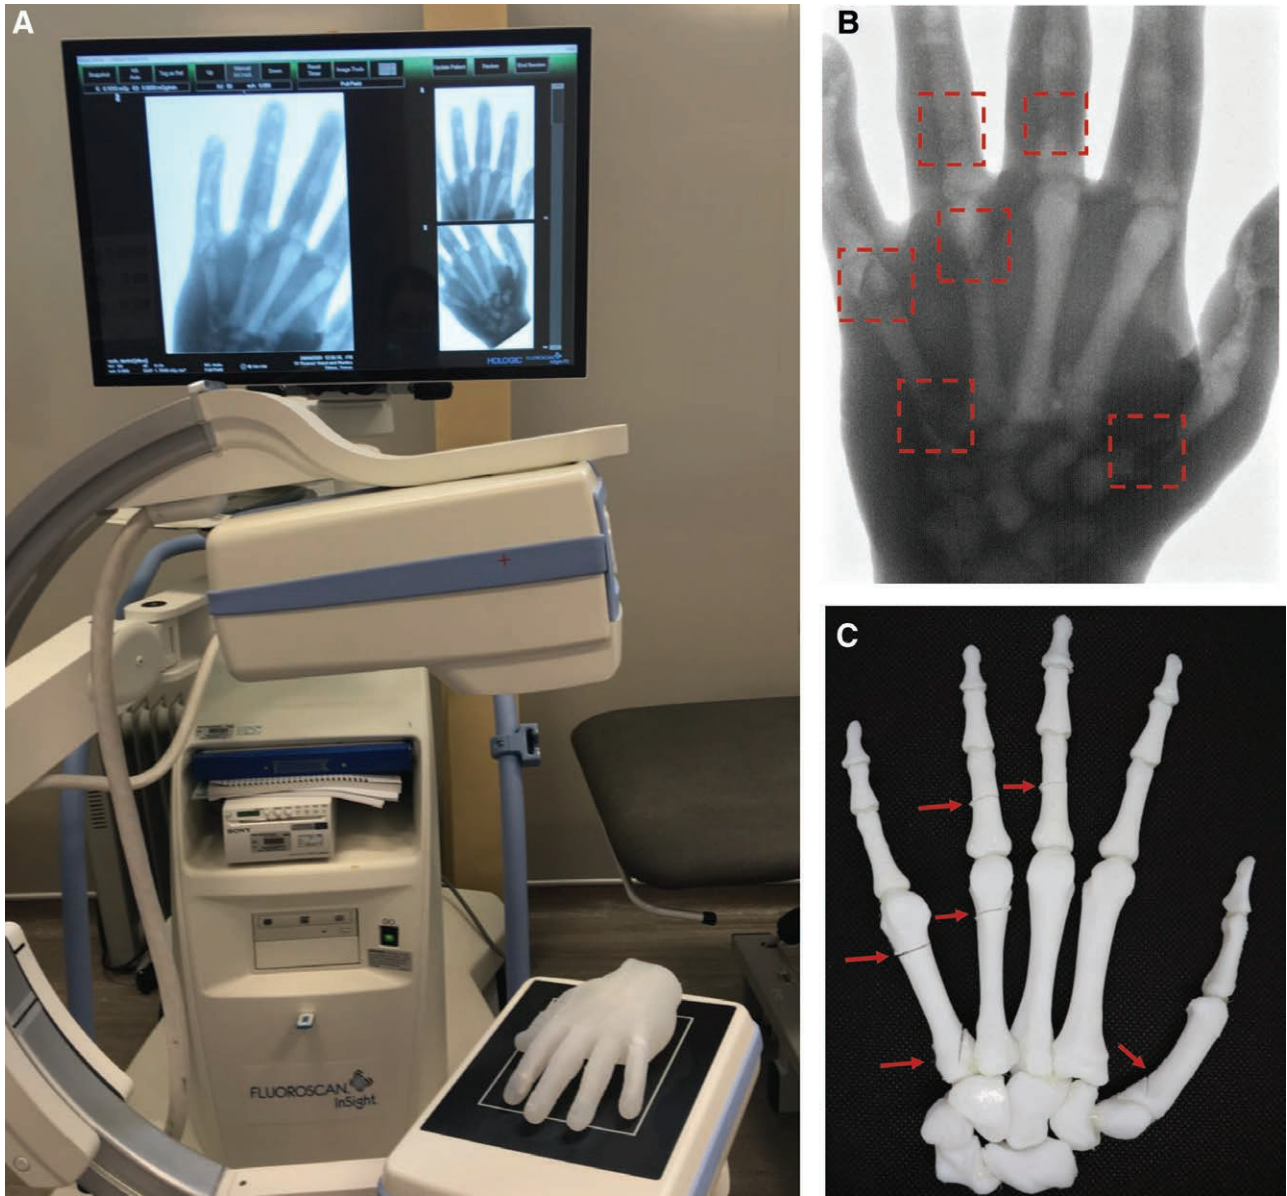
A, The silicone embedded 3D printed biomimetic model with the fracture patterns. B, The radiograph taken with mini C-arm provides evidence of significant contrast to mimic a normal hand radiograph. C, The 3D printed bone parts with the fracture patterns.
